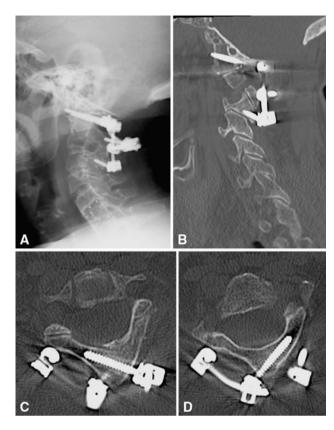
Patient 3: a lateral radiograph and b sagittal, CT scan showing a C0–C2–C3 fixation in a patient with C0–C1 assimilation. Translaminar screws have been used at C2 level (c, d) and lateral mass screws at C3
